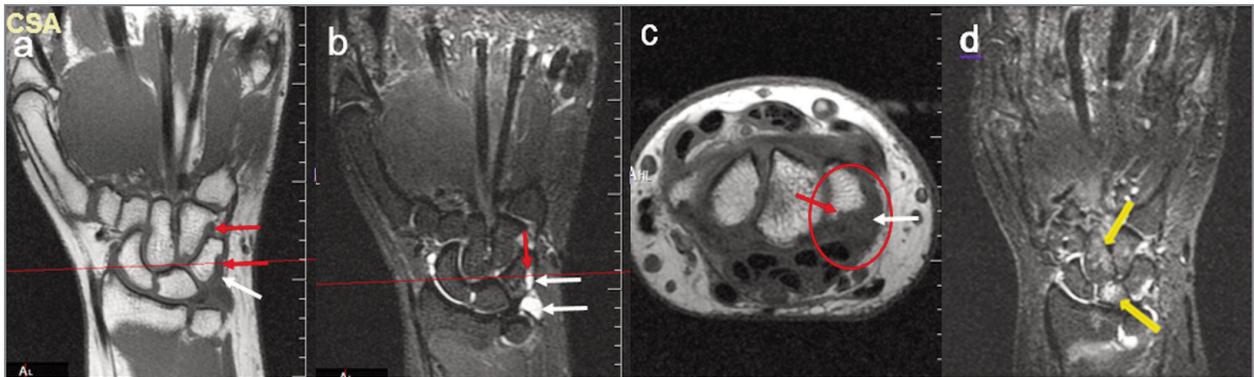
Hand-wrist MRI Coronal T1 and STIR in a clinically suspicious arthralgia (CSA) patient. First Carpal line lesions in a 59 year-old woman diagnosed with CSA. White arrows show synovitis in triquetrum bone; red arrow shows erosion in trapezoid; yellow arrows show bone marrow edema (osteitis) in hamate and scaphoid bones. A) T1 sequence synovitis in triquetrum and prestyloid-triquetral recess is seen hypointense (dark gray signal) (white arrow); erosions in triquetral and trapezoid cortical bones edge that usually show “no signal” (black signal), are seen hypointense in T1 due to joint effusion synovitis (red arrow). B) STIR sequence synovitis in triquetrum and prestyloid-triquetral joint recess is seen hyperintense (bright white signal) (white arrow); erosion in triquetrum due to effusion synovitis within it (red arrow). C) T1 axial slice (corresponding to the red line level in the coronal plane), synovitis in the triquetrum is seen hypointense (white arrow in red circle) and the erosion is seen hypointense (red arrow); D) BME/osteitis is seen hyperintense on STIR in lunare and capitate bones (yellow arrow).
